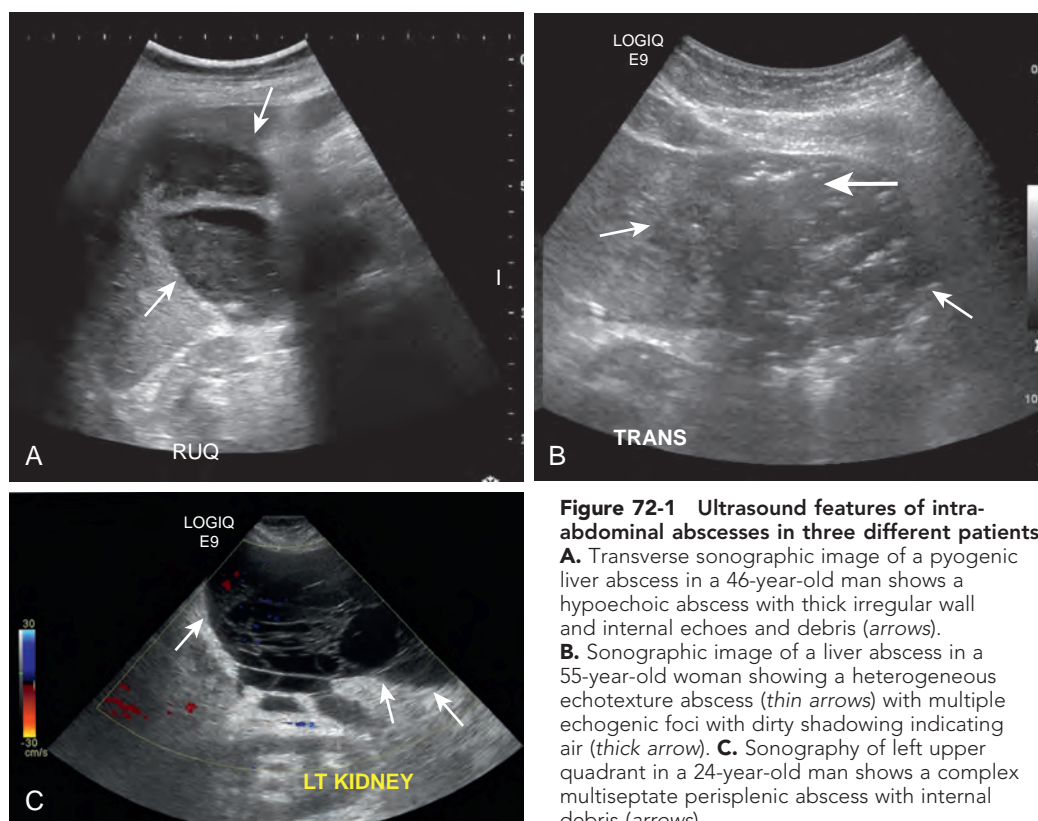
Ultrasound features of intra-abdominal abscesses in three different patients.
